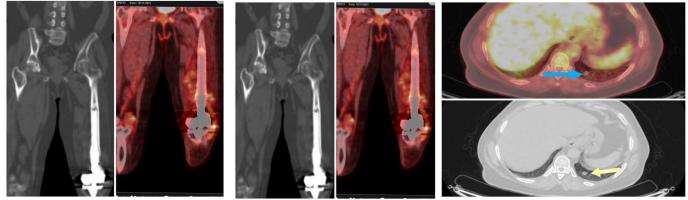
A 54 years old female patient with biopsy-proven left knee chondrosarcoma underwent surgical excision followed by chemotherapy for 3 months and referred for follow-up.(A): Coronal CT & fused PET/CT left knee show metallic prosthesis with clear surgical bed with mild surrounding regional FDG uptake but no sizable metabolically active destructive osseous lesions denoting local inflammatory changes and no local residual or recurrent tumor. (B): Axial CT& fused PET/CT chest show multiple RT middle lobe pulmonary nodules with no FDG uptake denoting no metabolic activity. (C): Axial CT& fused PET/CT chest
